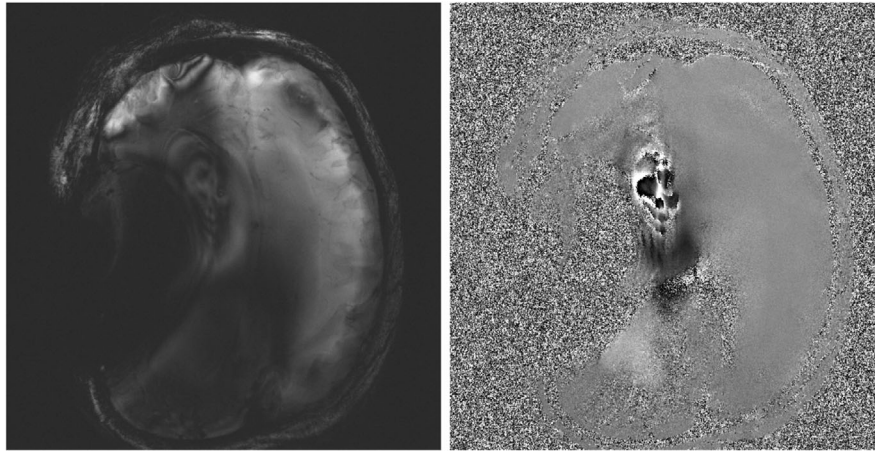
Example of artifact in phase-contrast MRI scan overlying complete catheter course in magnitude (left) as well as phase-contrast image (right).
